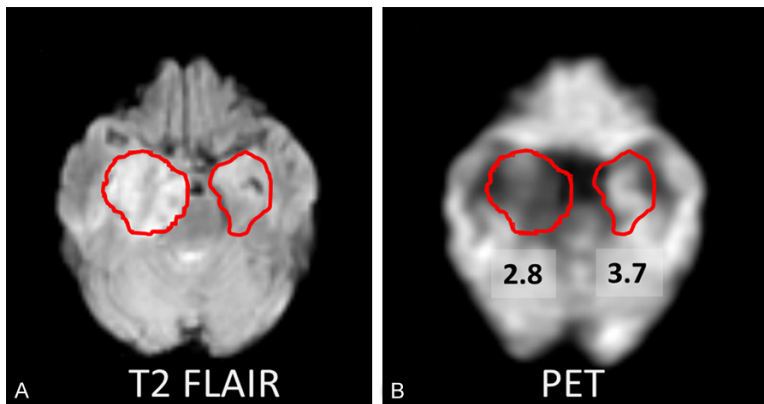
A: A 60-year-old male patient (case 7) shows abnormal signal and enlargement in right medial temporal lobe on T2 FLAIR image, as compared to the contralateral ROI. B: The co-registered FDG-PET and MRI image shows that this lesion has lower SUV (SUV=2.8) than contralateral homologous cortical region (SUV=3.7).
